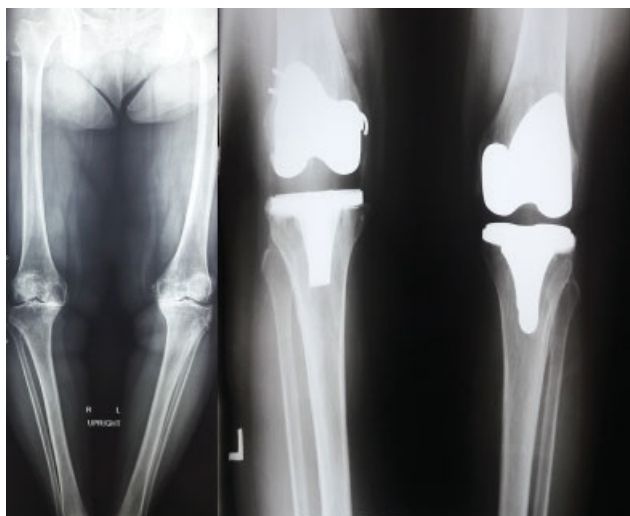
Preoperative and final follow-up radiography in patients under total knee replacement with medial epicondylar osteotomy and medial soft tissue release technique to correct severe varus malalignment in contralateral side.
